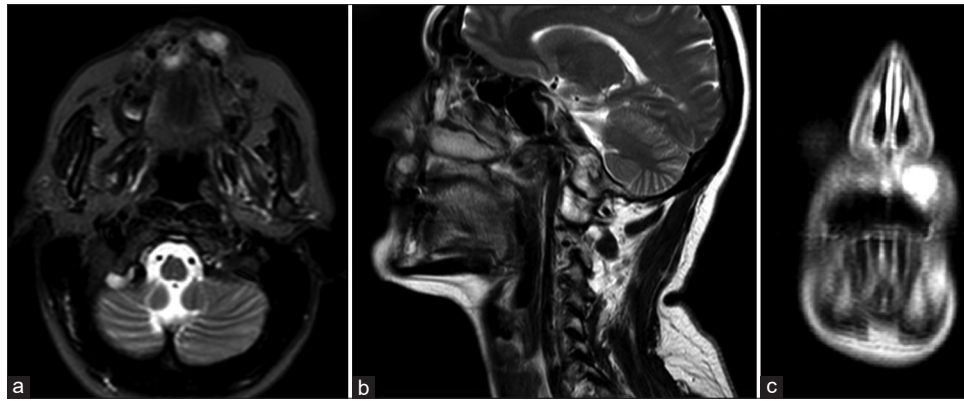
Magnetic resonance imaging scan. A cystic lesion sized $1.3 \times 1.1 \text{ cm}^2$ is present in the left mucosal area of the upper lip. (a) STIR sequence, axial plane, (b) T2-weighted image, sagittal plane, (c): STIR sequence coronal plane. STIR: Short-TI Inversion Recovery
